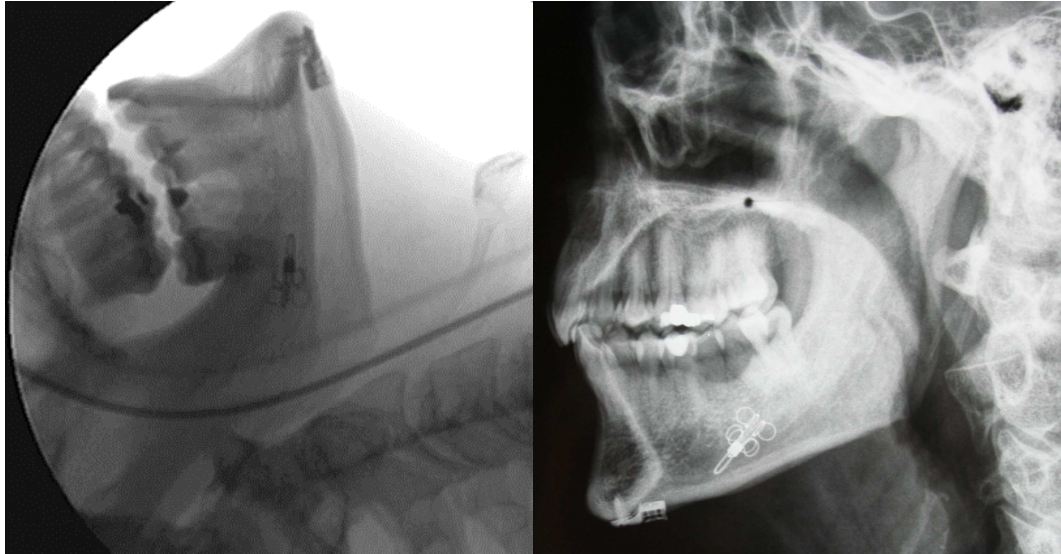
Patient A10. Left: position of tissue anchor at implantation with fluoroscopy. Right: tissue anchor 3 months post-op with X-ray.
